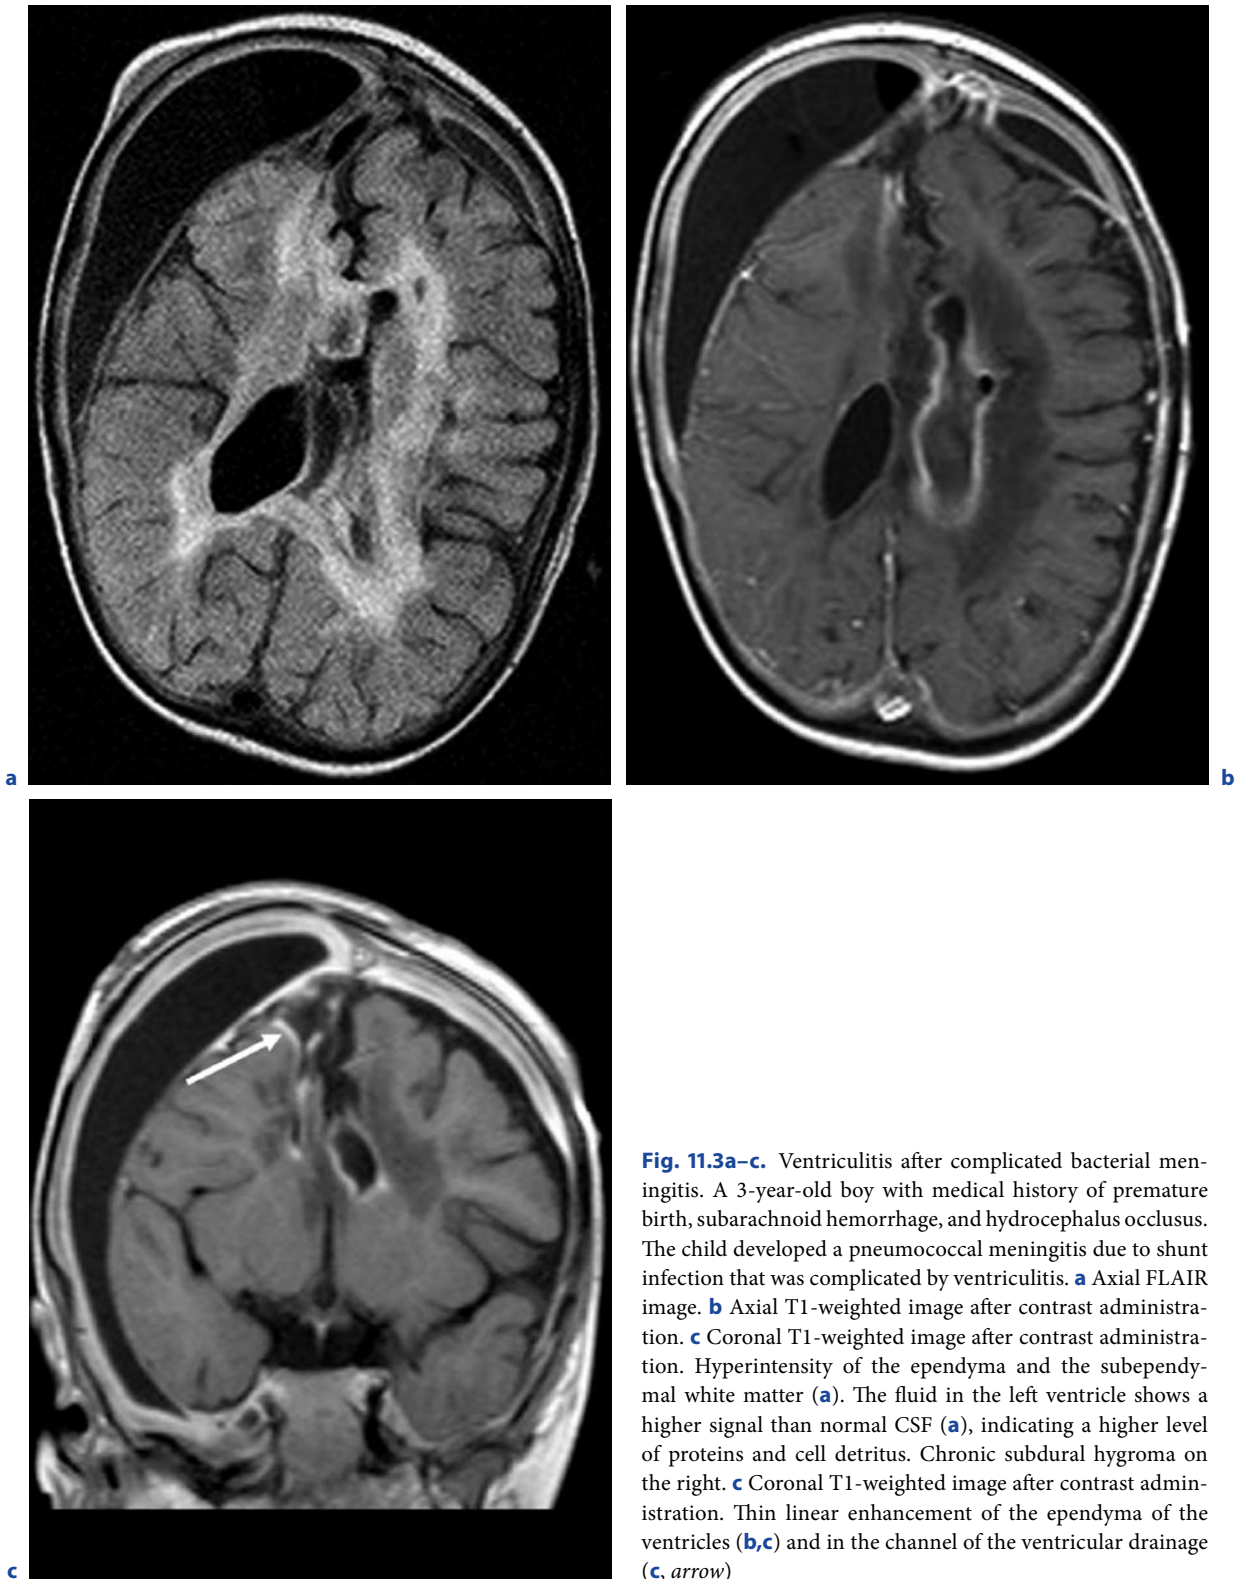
Ventriculitis after complicated bacterial meningitis. A 3-year-old boy with medical history of premature birth, subarachnoid hemorrhage, and hydrocephalus occlusus. The child developed a pneumococcal meningitis due to shunt infection that was complicated by ventriculitis. a Axial FLAIR image. b Axial T1-weighted image after contrast administration. c Coronal T1-weighted image after contrast administration. Hyperintensity of the ependyma and the subependymal white matter (a). The fluid in the left ventricle shows a higher signal than normal CSF (a), indicating a higher level of proteins and cell detritus. Chronic subdural hygroma on the right. c Coronal T1-weighted image after contrast administration. Thin linear enhancement of the ependyma of the ventricles (b,c) and in the channel of the ventricular drainage (c, arrow)
